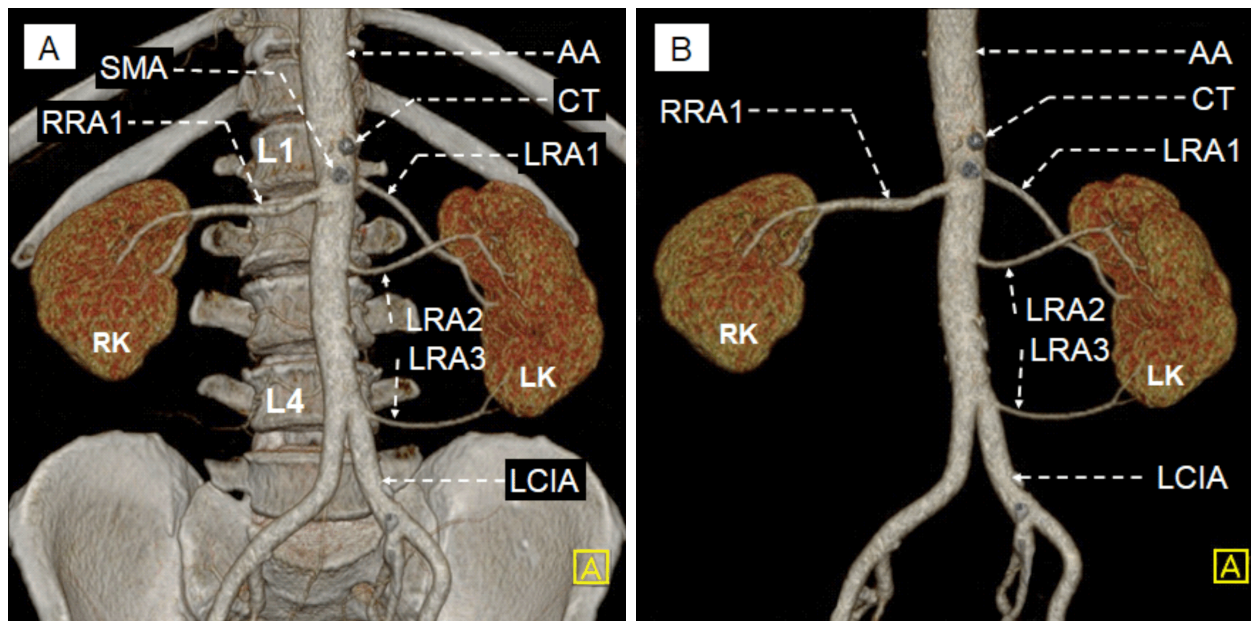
MDCT angiographies with 3D reconstruction of the kidneys with the abdominal part of aorta and renal arteries – coronal aspect: (A) VRT image with the kidneys in situ and the relationship of the renal arteries to vertebral bodies and costal arches; (B) VRT image after subtraction of the bone structures. MDCT: Multidetector computed tomography; 3D: Three-dimensional; VRT: Volume rendering technique; RK: Right kidney; LK: Left kidney; AA: Abdominal part of aorta; CT: Celiac trunk; SMA: Superior mesenteric artery; LCIA: Left common iliac artery; RRA1: Right renal artery 1; LRA1: Left renal artery 1; LRA2: Left renal artery 2; LRA3: Left renal artery 3.
